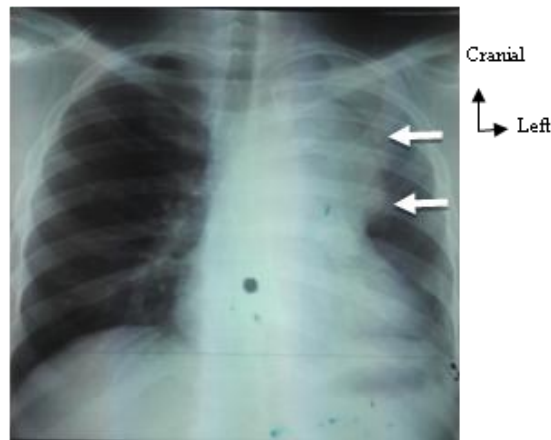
Front chest X-ray showing a left mediastinal enlargement (arrows) and cardiomegaly
